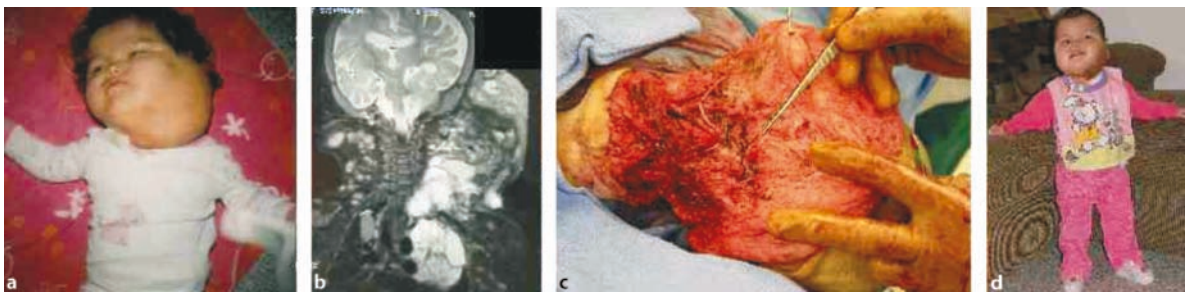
Patient with large cervicofacial/thoracic lymphatic malformation, before surgery (a), preoperative MRI (b), intraoperative view after debulking (c), and postoperative (d)
